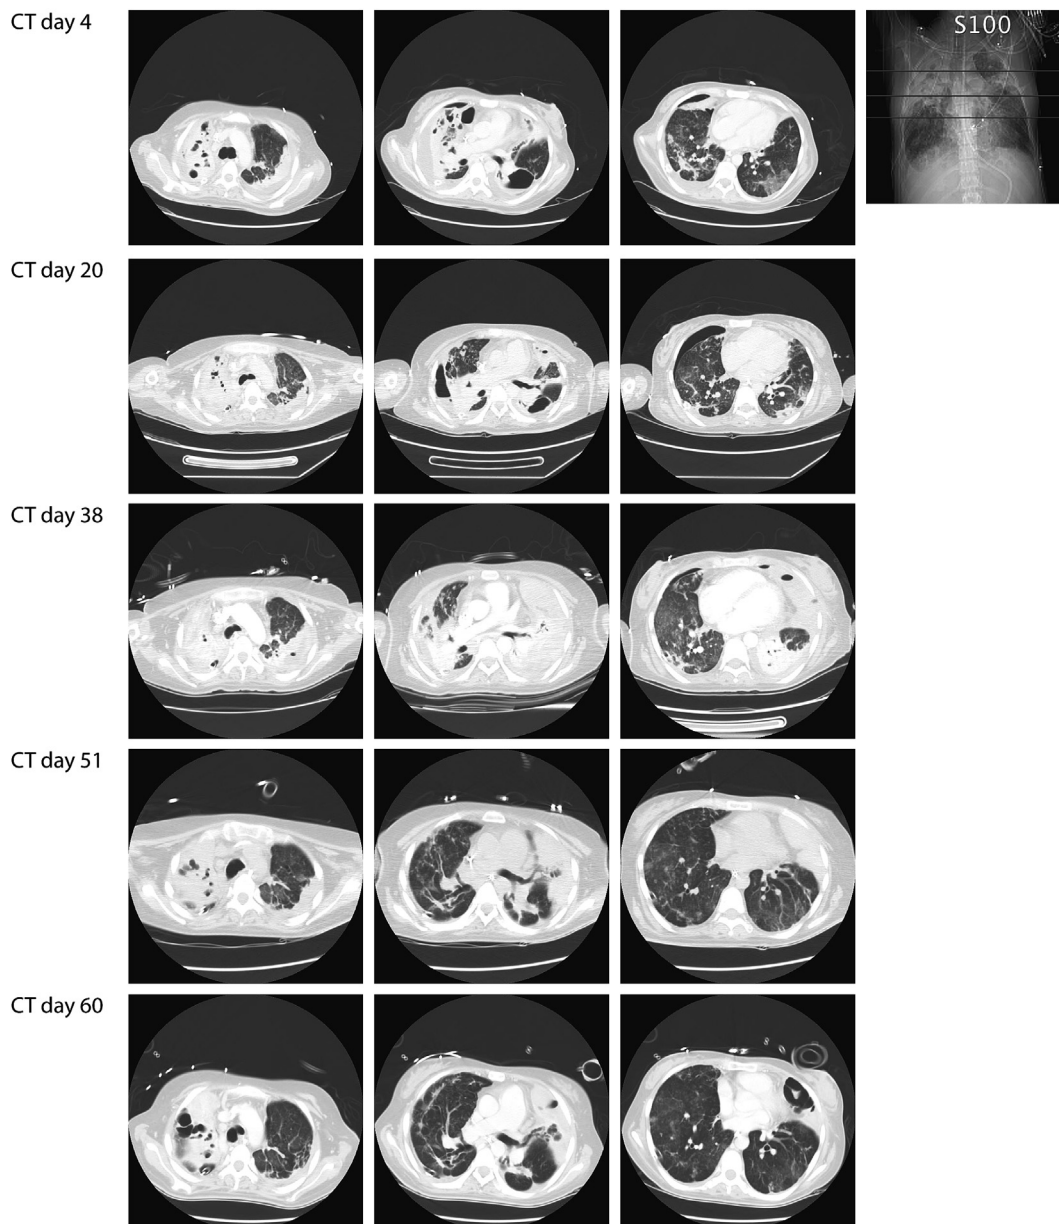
Computed tomography scan progress.
